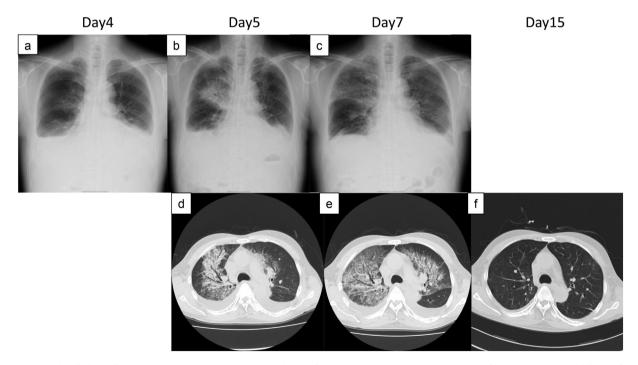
Chest X-ray and CT findings after TACE. (a) On day 4, A chest radiograph obtained following treatment with TACE showed an infiltration in the right middle lung fields. (b) On day 5, the infiltration had progressively expanded and become denser, and new infiltrations were visible in the left lower lung field. (c) On day 7, the infiltrations had been replaced with ground glass opacities and expanded to the whole lung field. (d) Chest CT on day 5 revealed dense consolidations, an air bronchogram, and thickening of the interlobular septum in both upper lobes. These consolidations involved traction bronchiectasis. Bilateral pleural effusions were present, but no mediastinal lymph node enlargement was seen. (e) On day 7, these dense consolidations had expanded and been replaced by GGOs, and the thickening of the interlobular septum was more marked. (f) On day 15, the radiographic findings had dramatically improved.
